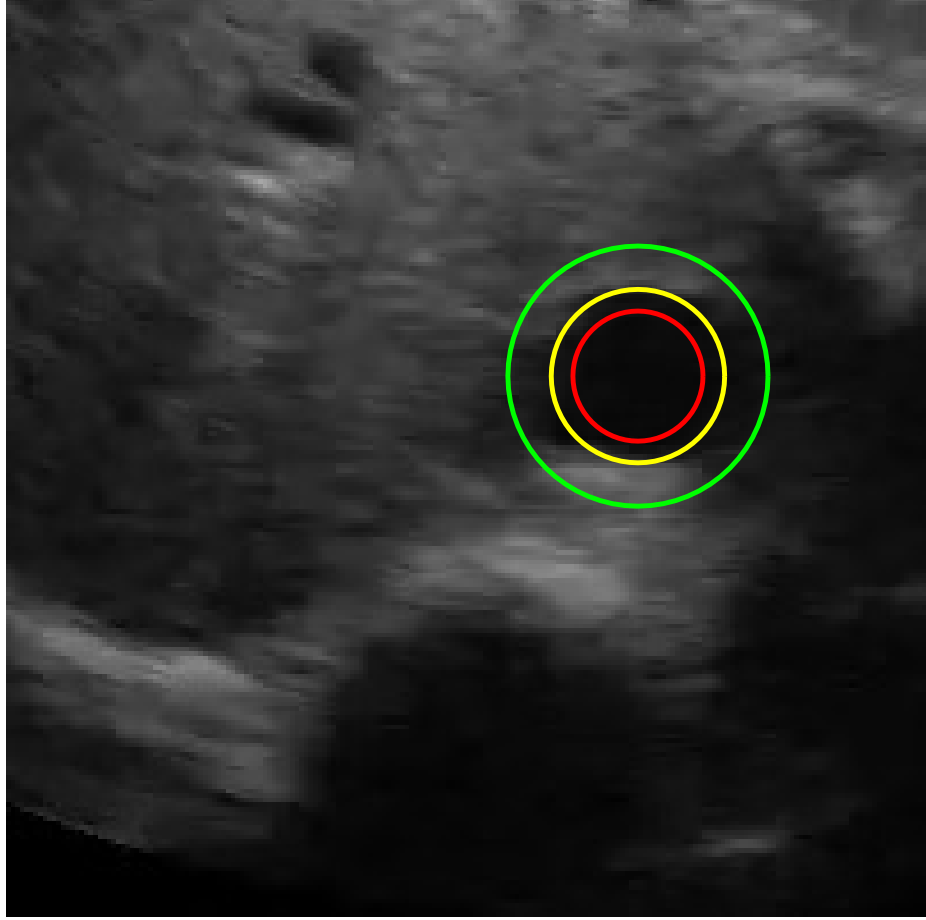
A typical ultrasound image of IVC.
